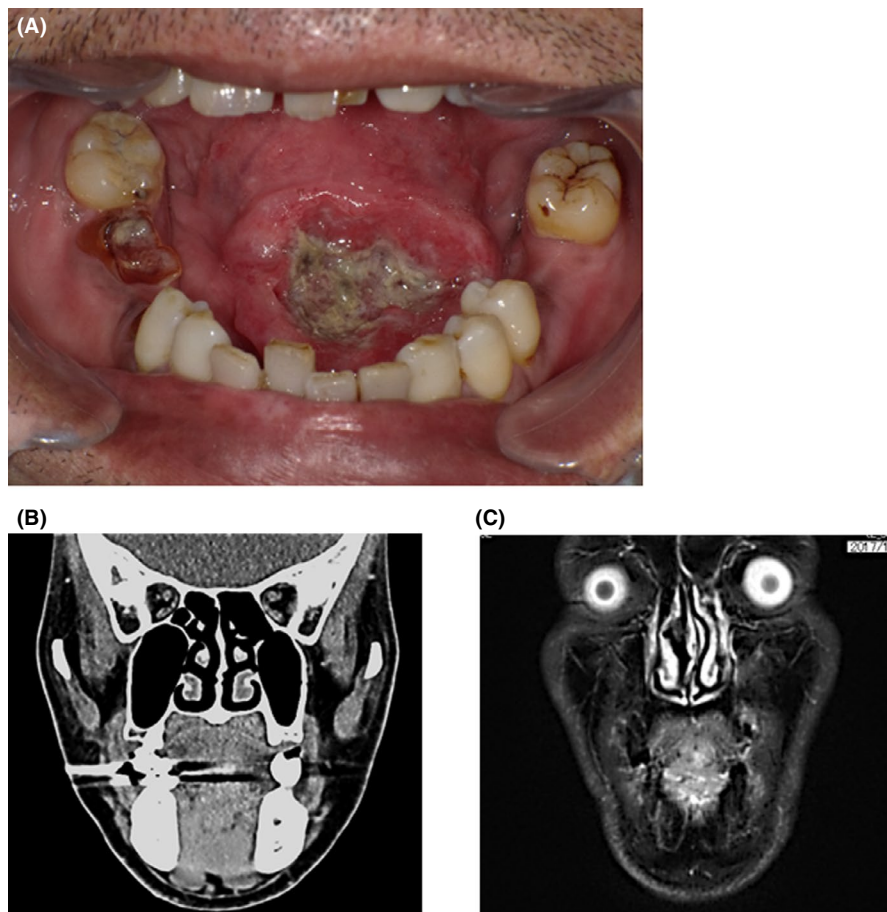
(A) An ulcerated lesion on the left side of the floor of the buccal cavity. (B) Non-homogeneous enhancing lesion on the left side of the sublingual region, extending through the mylohyoid muscle, on computed tomography imaging. (C) Magnetic resonance T2-weighted imaging
